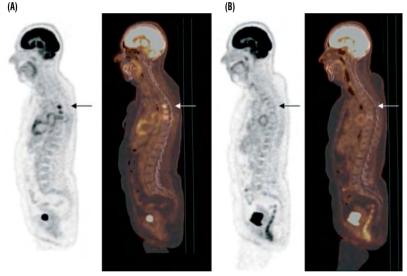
Rising CA 15-3 level (50 U/mL) in patient treated for breast carcinoma 18 years ago. FDG PET/CT revealed foci in thoracic spine (arrow) (A - left image: sagittal FDG PET, right image: PET/CT fusion). Eight months later, complete metabolic response after treatment by letrozole (B).
